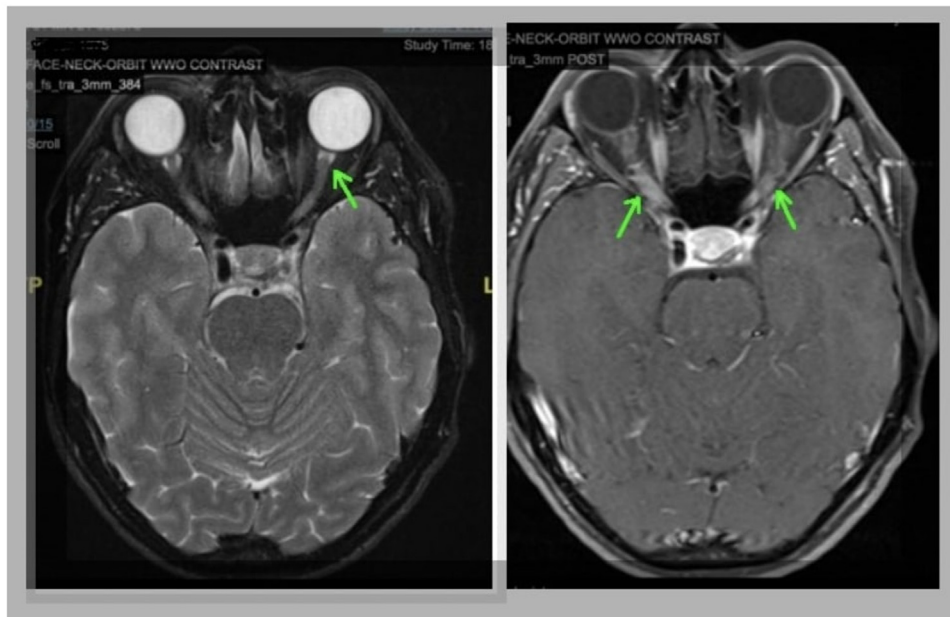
A) T₂ sequence demonstrates increased signal of the optic nerves. (B) Gadolinium-enhanced magnetic resonance imaging sequence demonstrates enhancement of the bilateral optic nerves. Retrobulbar fat surrounding the optic nerves also demonstrates enhancement. Diffusion restriction (not pictured) was evident on diffusion-weighted imaging in the intraorbital and orbital apex segments of the optic nerves with relative sparing of the prechiasmatic optic nerves.
